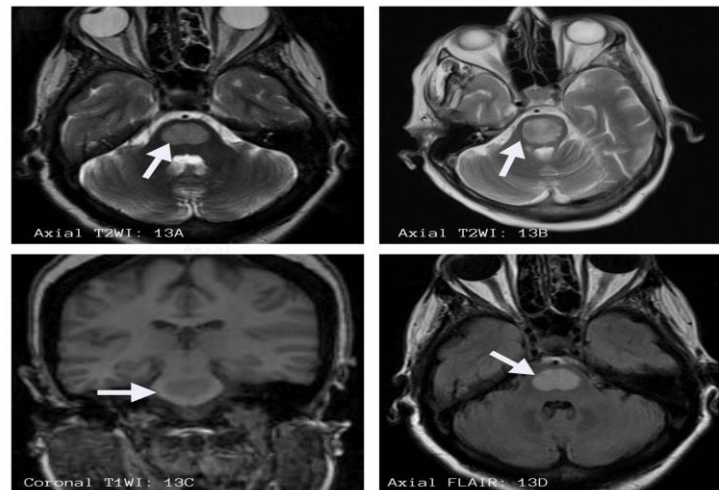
Images from a subject with osmotic demyelination syndrome showing T2WI and FLAIR hyperintense lesions on figures (13A), (13B), and (13D) respectively. T1WI hypointense lesions shown in (13C)
